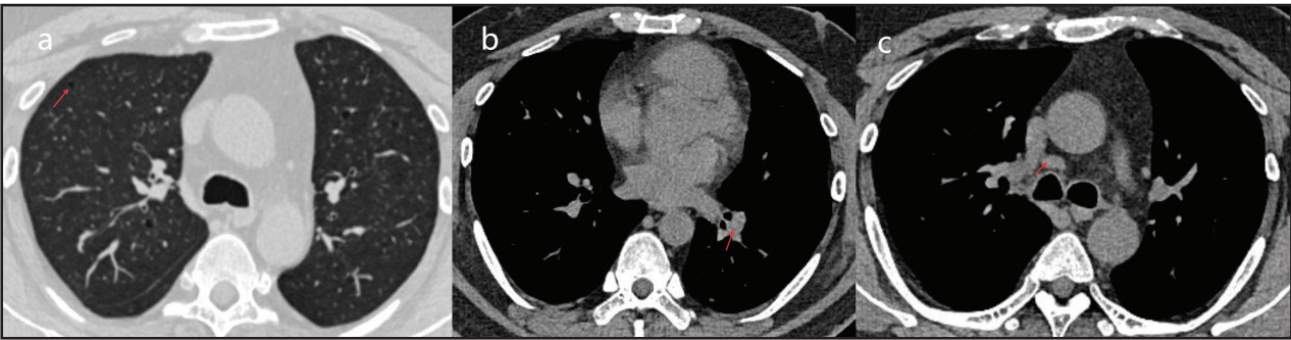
Chest CT (August 29, 2026). (a) Lung window showing stable bilateral small cystic lesions. (b and c) Mediastinal window showing continued reduction of the left lower lobe mass, with stable mediastinal lymph nodes.
